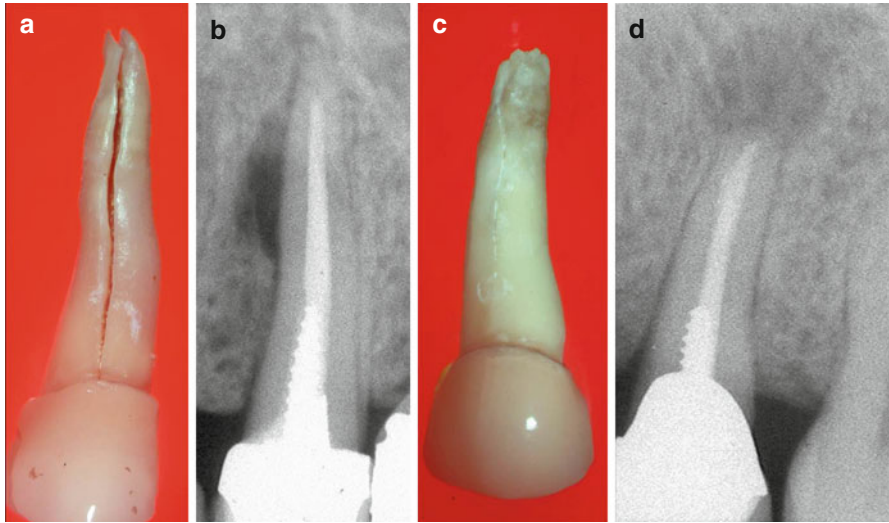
(a–d) Two longitudinal VRFs are presented. The segments are separated as in Fig. 5.12a, and the parts are still attached to each other in the other extracted tooth as in Fig. 5.12c. Although both VRFs are to the full length of the root, the radiolucency in the bone in case (a) is limited to the lateral part of the middle third of the root (b), and in the tooth (c), the radiolucency is limited to the periapical area (d), which is not typical to a vertically fractured tooth but rather to the failure of root canal treatment
